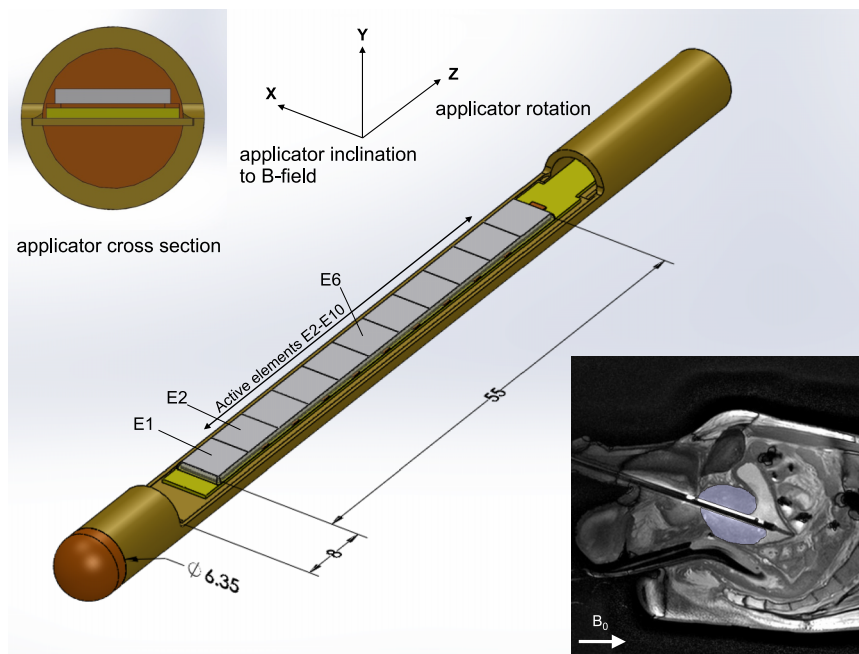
Applicator design. Brass tube with polymide end cap. In the center, a section of tube is removed to provide exposure of a rectangular transducer element to the surrounding tissue. This window is covered by a thin vinyl membrane (not pictured). A circuit board and floor plate, on which the transducer rests, are approximately centered in the applicator along the y -axis. All rotations are of right-handed sense, as are the coordinate axes. Insets at top-left and bottom-right show a cross section of the device and a sagittal MR image of the device being used in a patient, respectively. The prostate gland is indicated in the MR image.
